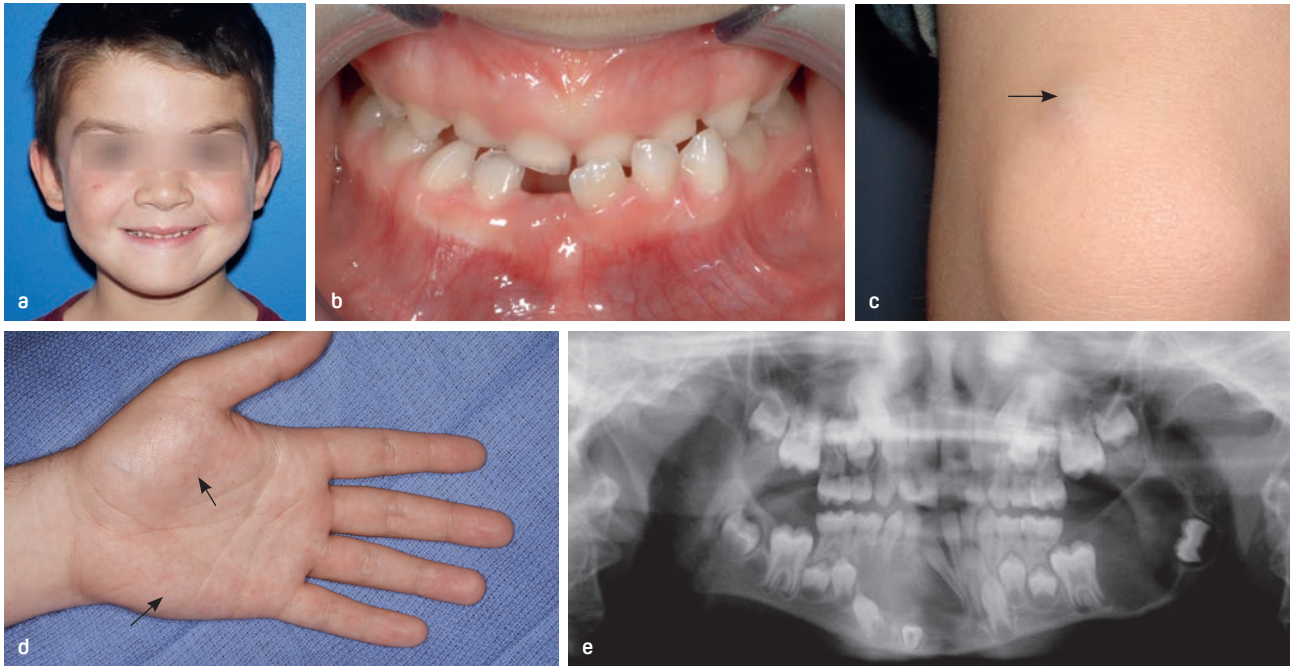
(a) Frontal photograph of 8-year-old boy at presentation with jaw cysts. There is mild frontal bossing and hypertelorism. (b) Intraorally, there is fullness of the sulcus anteriorly and on the left posteriorly with displacement of teeth in the anterior mandible. (c) Cystic lesion over right knee (arrow). (d) Palmar pitting (arrow). (e) Panoramic radiograph shows large radiolucent, expansile lesions at left mandibular posterior and symphysis regions displacing teeth. (See also Fig 5-34.)
